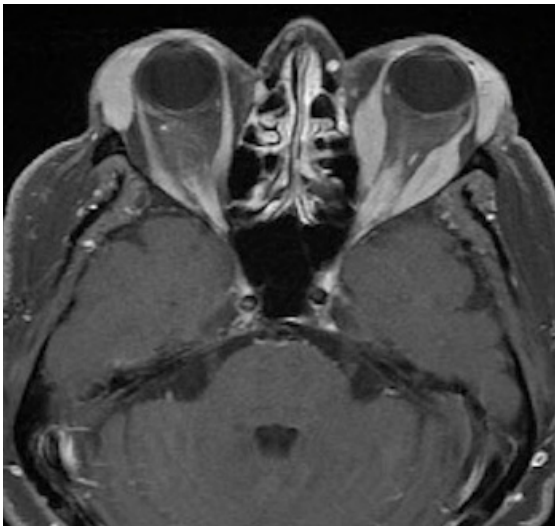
Bilateral symmetrical exophthalmos, hypertrophy in the periorbital muscles, and hypertrophy in the lacrimal glands were observed in magnetic resonance imaging.
